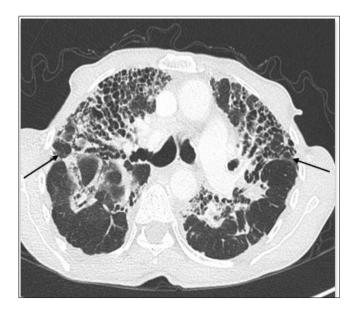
Axial chest CT scan: multiple microcystic images creating a honeycomb appearance with thickening of the septal lines, suggesting bilateral diffuse interstitial fibrosis
